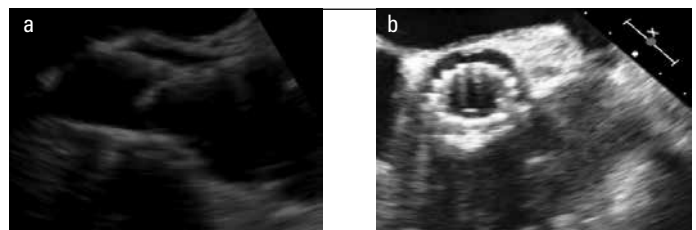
Transesophageal echocardiography 10 days after initiation of antibiotic treatment and heparinization showing disappearance of the mass without any residual structural lesion of the CoreValve® prosthesis (white arrows). a) long-axis view; b) short-axis view
